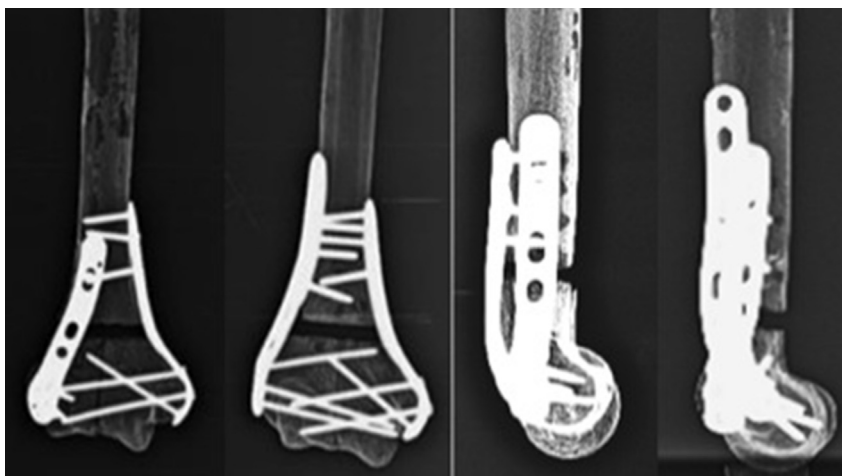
Anteroposterior and lateral radiographs of the orthogonal and parallel plating samples.
